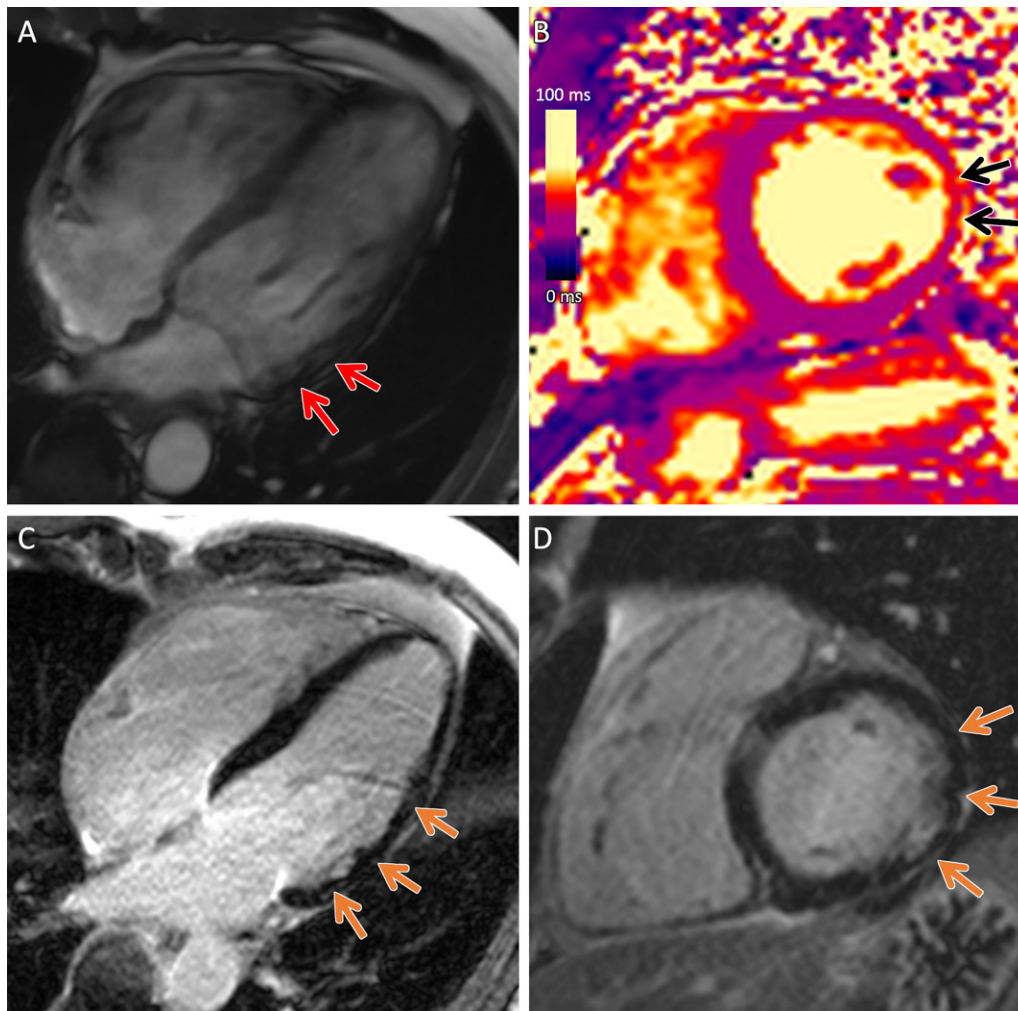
Arrhythmogenic cardiomyopathy with *TMEM43* pathogenic variant (p.Ser358Leu). Cardiac 3-T MR images in a male patient between 50 and 59 years of age (exact age not provided due to potential reidentification risk) with chest pain and premature ventricular beats at Holter monitoring. The patient had a family history of arrhythmogenic cardiomyopathy. (A) Four-chamber steady-state free precession MR image demonstrates subepicardial chemical shift artifact along the basal to midventricular lateral left ventricular wall (red arrows). (B) Native T2 map demonstrates regional high T2 values at the midventricular inferolateral wall (black arrows). (C) Four-chamber and (D) short-axis late gadolinium enhancement images demonstrate subepicardial late gadolinium enhancement involving the basal to midventricular anterolateral and inferolateral wall (orange arrows).
